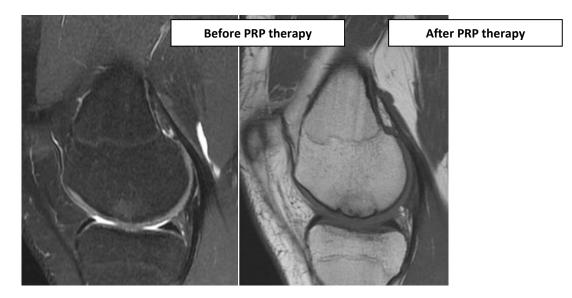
MRI image of Knee cartilage before and after PRP therapy. Before PRP, the cartilage thickness was reduced, but after the PRP therapy significant improvement in the cartilage thickness was observed (Akman et al., 2016)
